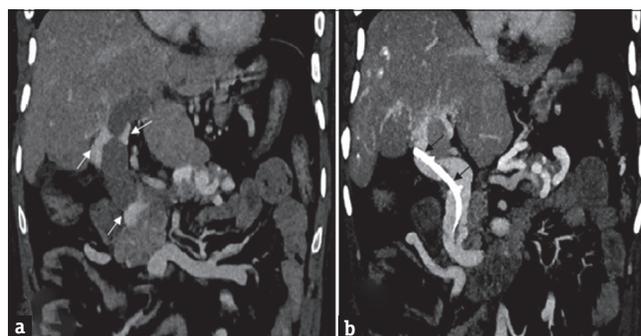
(a and b) contrast-enhanced computed tomography abdomen during portal venous phase in coronal plane showing multiple paracholedochal collaterals (white arrow) with dilated common bile duct. Tip of biliary stent (black arrow) is misplaced and seen within one of the larger paracholedochal collateral
